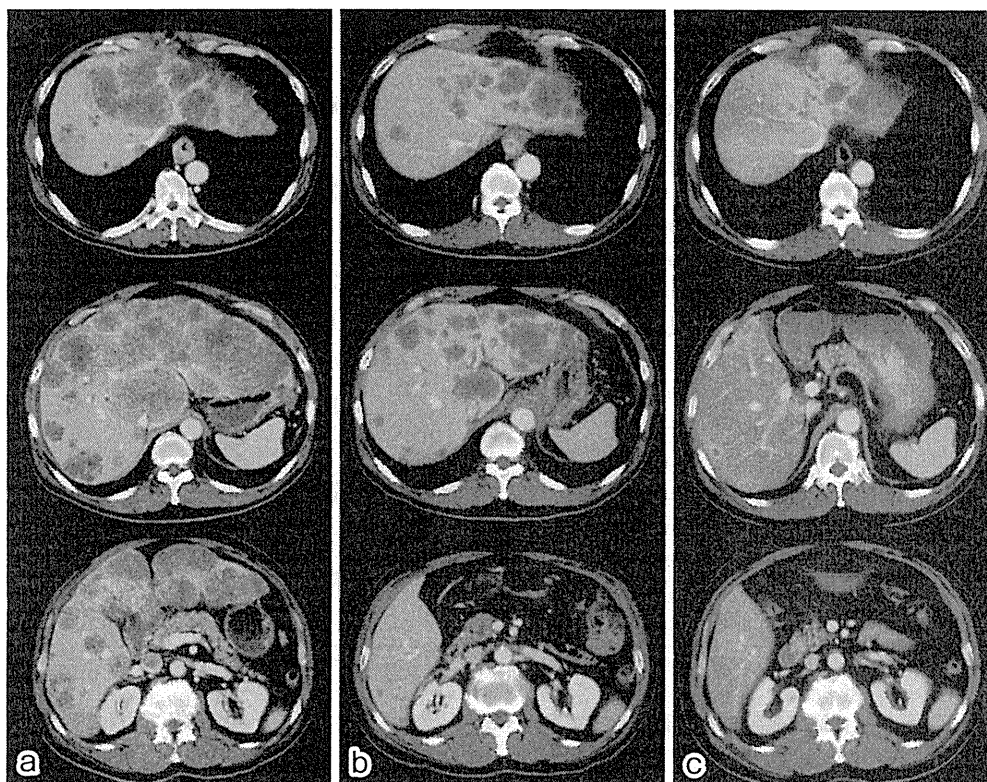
腹部造影 CT 検査 a) 治療開始前：肝両側に転移性病巣が多発し肝は著明に腫大しており，原発巣の食道壁は肥厚している． b) 第 27 病日：腫瘍は縮小し肝腫大も軽減している． c) 第 179 病日：さらに腫瘍は縮小している．
